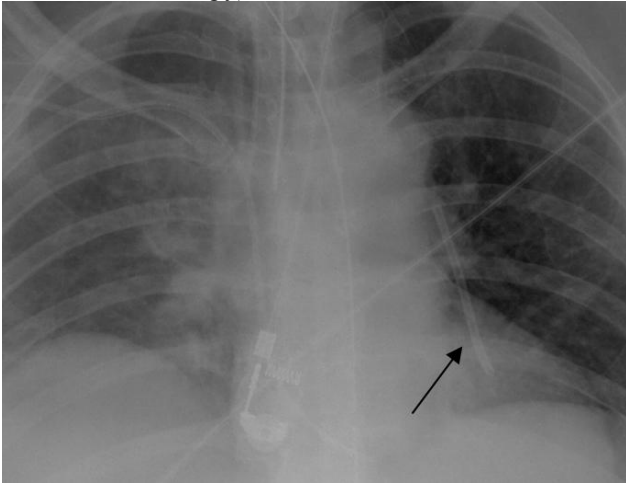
Coned down frontal chest radiograph demonstrating a catheter fragment projecting in the left pulmonary artery (arrow).
